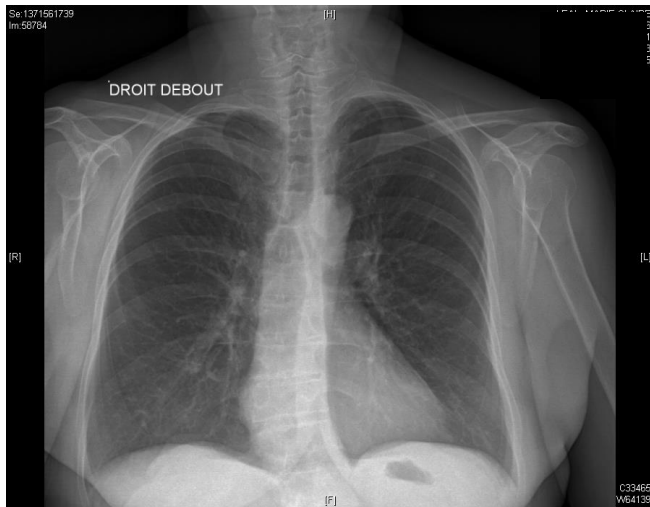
On chest control X-ray at 3 months of antibiotics, bilateral lung infiltrates had totally disappeared.
